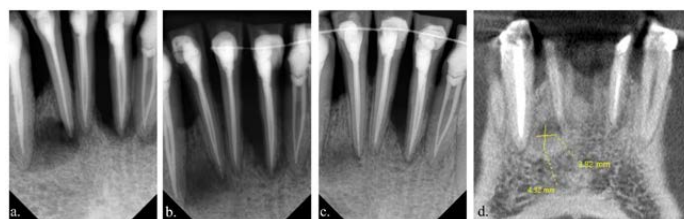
a. 3 month follow up, b. 6 months follow up, c. 1-year follow up, d. CBCT one year follow up.
